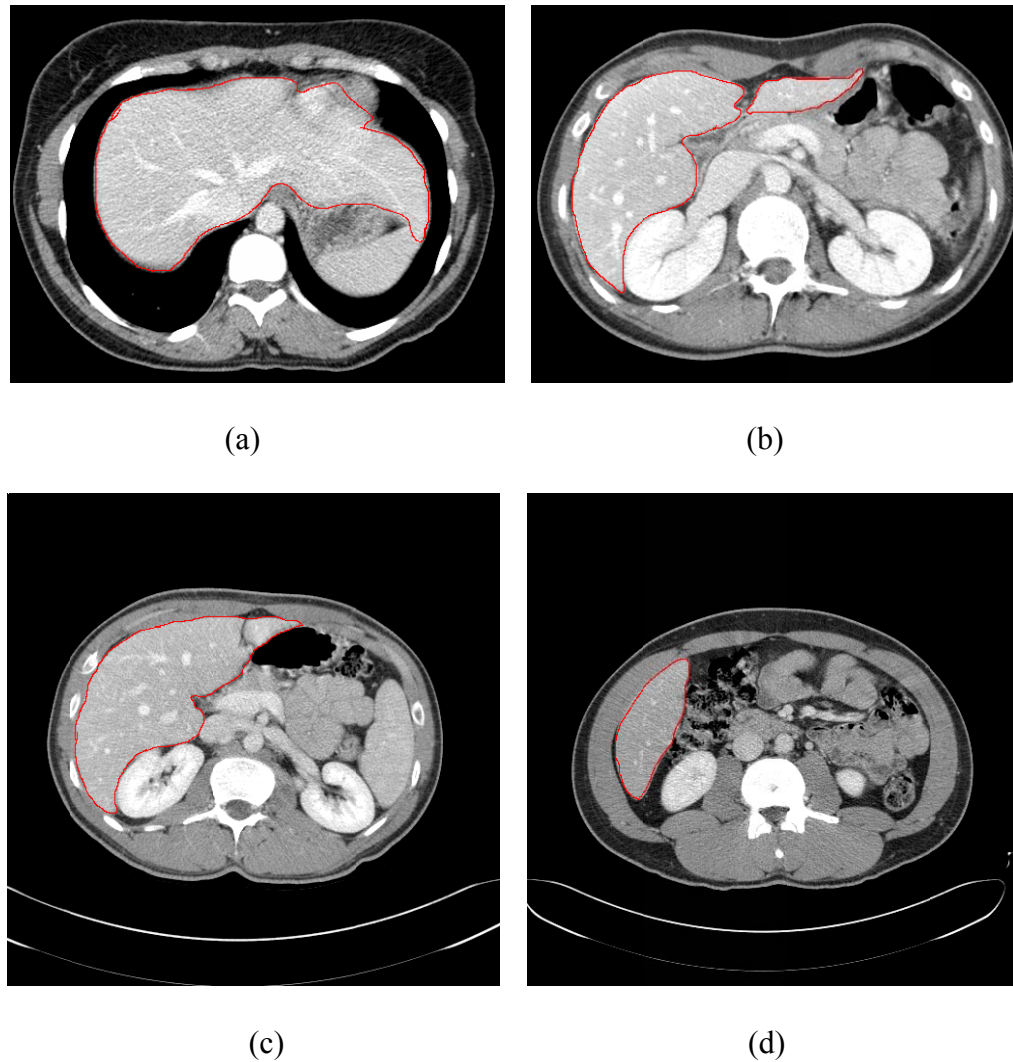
Examples of abdominal CTA images (a) Very low contrast between liver and vena cava. (b) Low contrast between liver and muscle tissue (c) High contrast between liver and adjacent tissues (i.e. right kidney, muscle, vena cava) (d) Atypical liver shape that causes unclear boundary with spleen.
